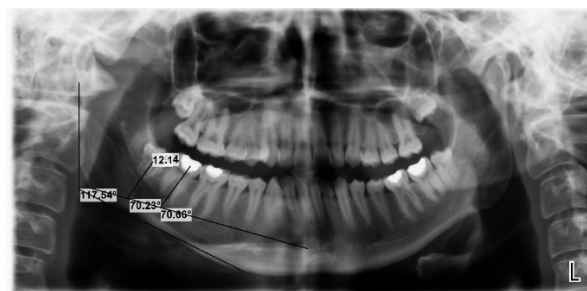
Measurement of panoramic radiography
